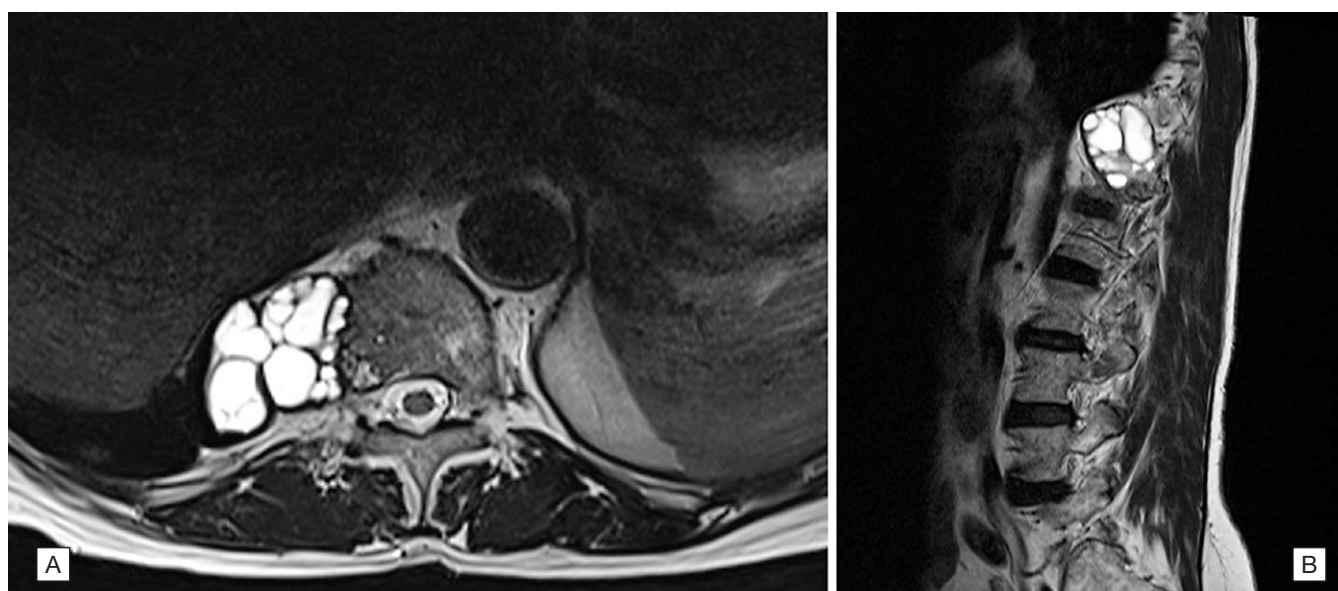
T2-weighted gadobutrol-enhanced MRI showing multiloculated paravertebral cysts on the right at the level of D11 and D12. [A] - Axial view; [B] - Sagittal view.
